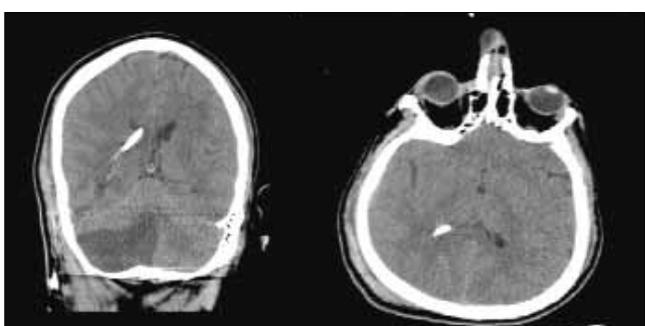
The patient's brain CT scan taken post-surgery
